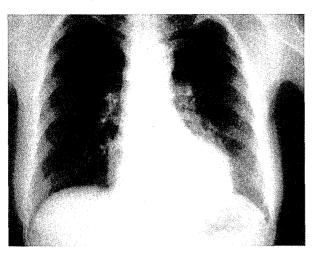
Chest radiograph showed that a large pulmonary mass was located in the left lower lobe.
